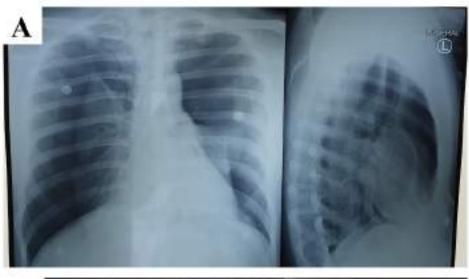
A Chest X-ray of anterior-posterior and left lateral before chest tibe insertion; B. Chest X-ray of anterior-posterior and left lateral after chest tibe insertion.
